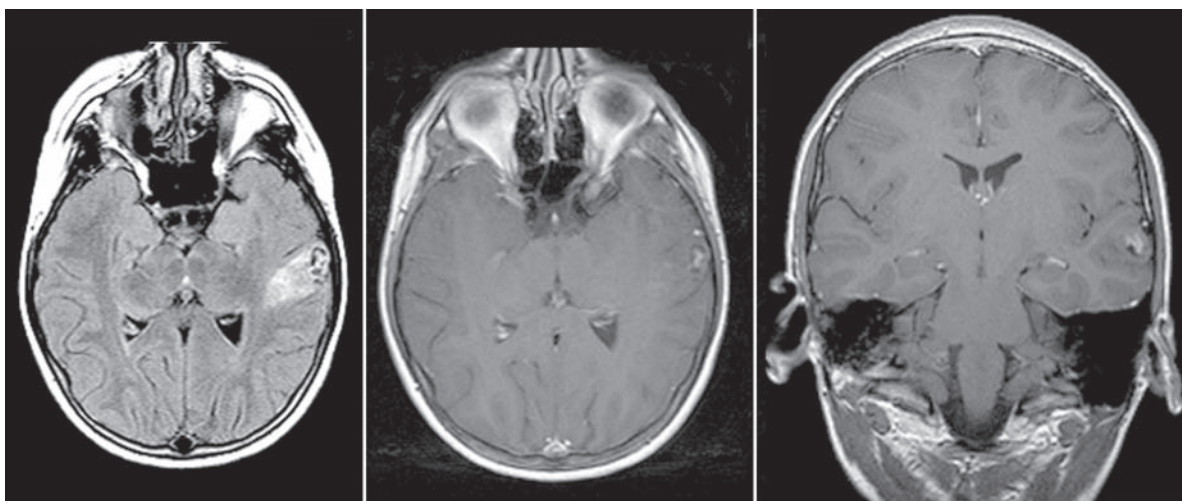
Ganglioglioma of the left temporal lobe. The tumor is hyperintense and partially cystic on proton-weighted images (*left*). On T1-weighted images the mural module within the cyst
